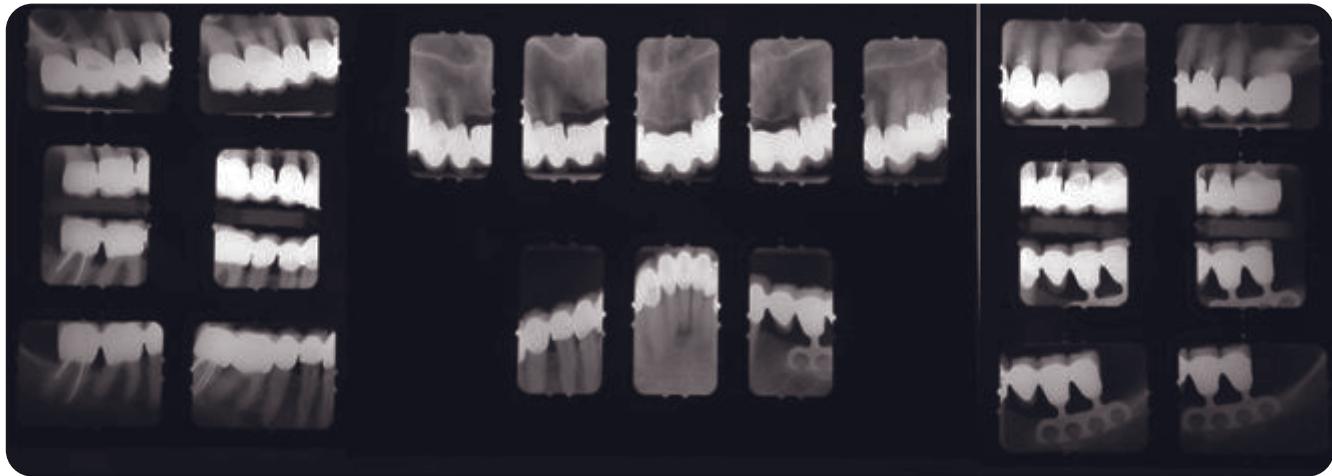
Pretreatment radiographs. The blade implant and restoration is 20+ years old and has been, and is currently, problem-free. The lower prosthesis is a fixed partial denture from the lower left last molar to the lower right lateral incisor. The prosthesis was sectioned between the lower left first bicuspid and cuspid. The lower left 4-tooth fixed partial denture remained.
